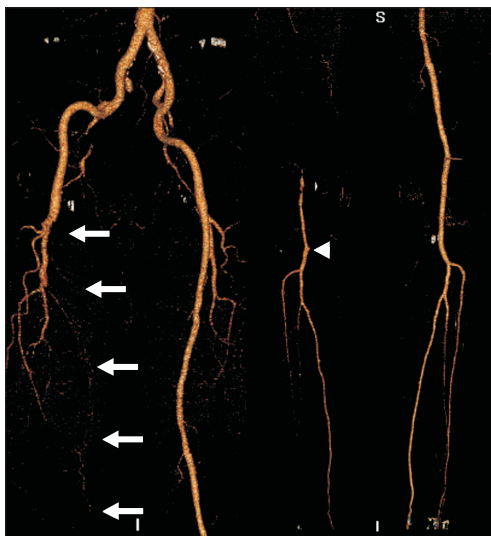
Preoperative computed tomography angiography demonstrated long-segment femoropopliteal occlusion with total graft occlusion (white arrows). The stump of the previous distal anastomosis was located at the below-knee popliteal artery (arrowhead).
